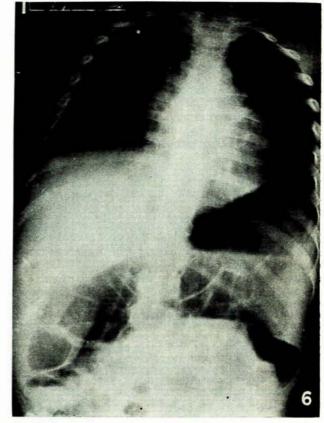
Case 3-X-ray showing the degree of gaseous distension of the bowel following decompression.
